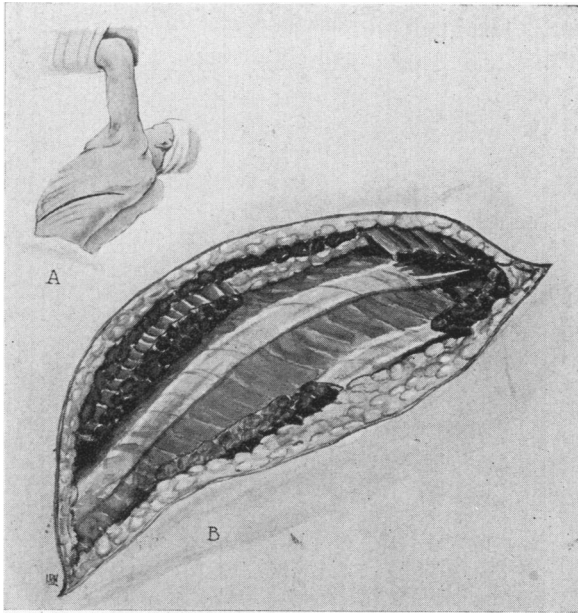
Incision (A) and exposure (B) of the 7th rib for transthoracic vagotomy.
